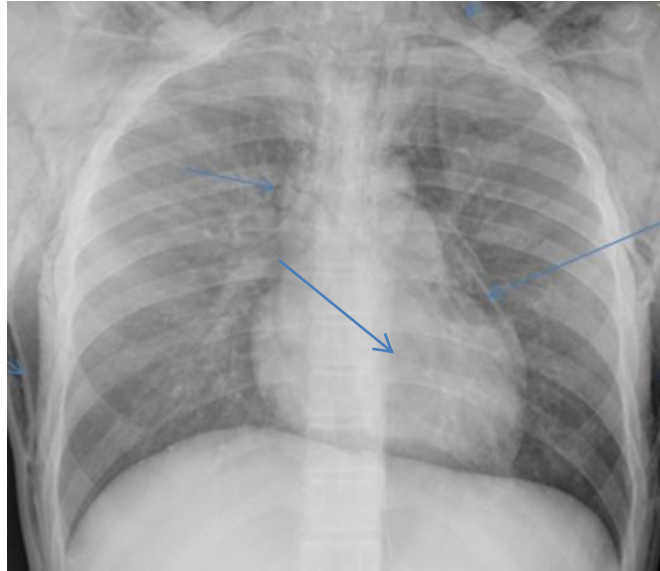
Initial Chest x-ray showing pneumomediastinum and subcutaneous emphysema
